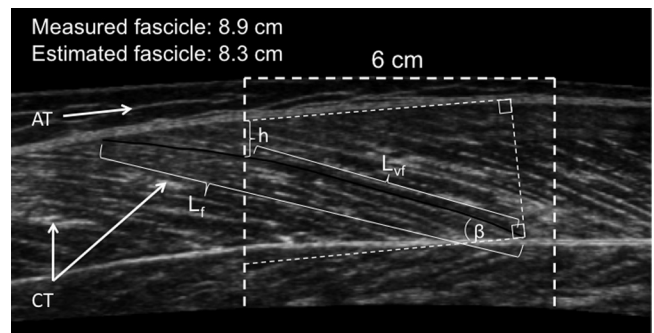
Example VL extended field-of-view ultrasonography (EFOV US) image. The white dashed line represents the 6-cm-wide single scan used for comparison; the black continuous line is the analyzed fascicle (L_f). L_{vf} is visible part of the fascicle on the 6 cm scan, β is the angle between the fascicle and a line in parallel with the superficial aponeurosis, and h is the vertical distance from the superficial aponeurosis to the crossing point with the fascicle. Adipose (AT) and connective tissue (CT) markings, as shown, were used to ascertain that the imaging plane was similar in repeated scans (see MATERIALS AND METHODS). In this image, the fascicle length difference between directly measured and estimated fascicle lengths was 4.8%.
